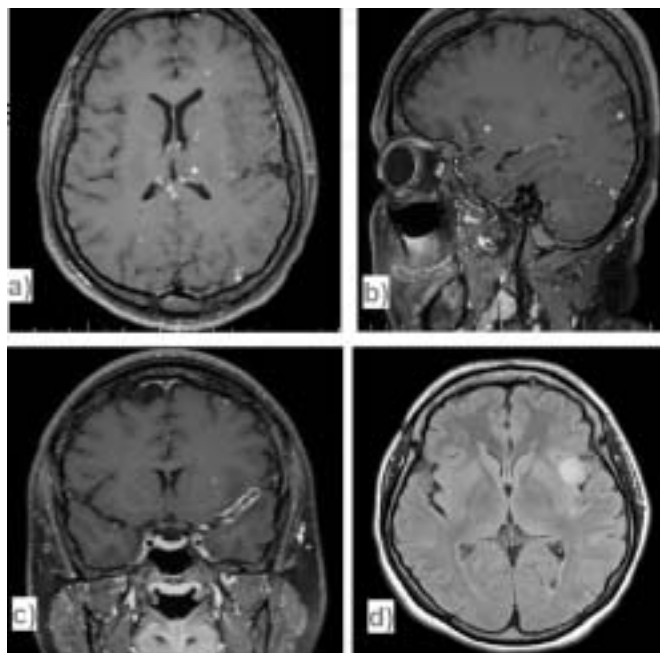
Contrast enhanced MRI Brain (a) axial and (b) sagittal images showing multiple nodular enhancing lesions in both cerebral hemispheres. (c) Enhancing leptomeningeal thickening in left sylvian fissure. (d) T2 FLAIR hyperintensity in left insular region and temporal lobe.
